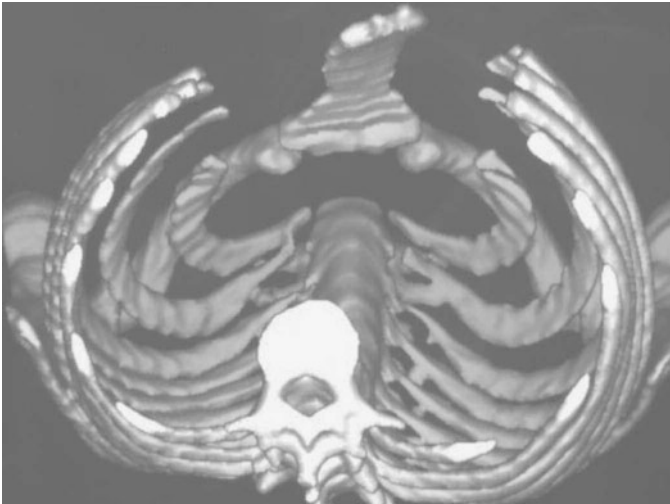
CT reconstruction showing asymmetric unilateral PC
